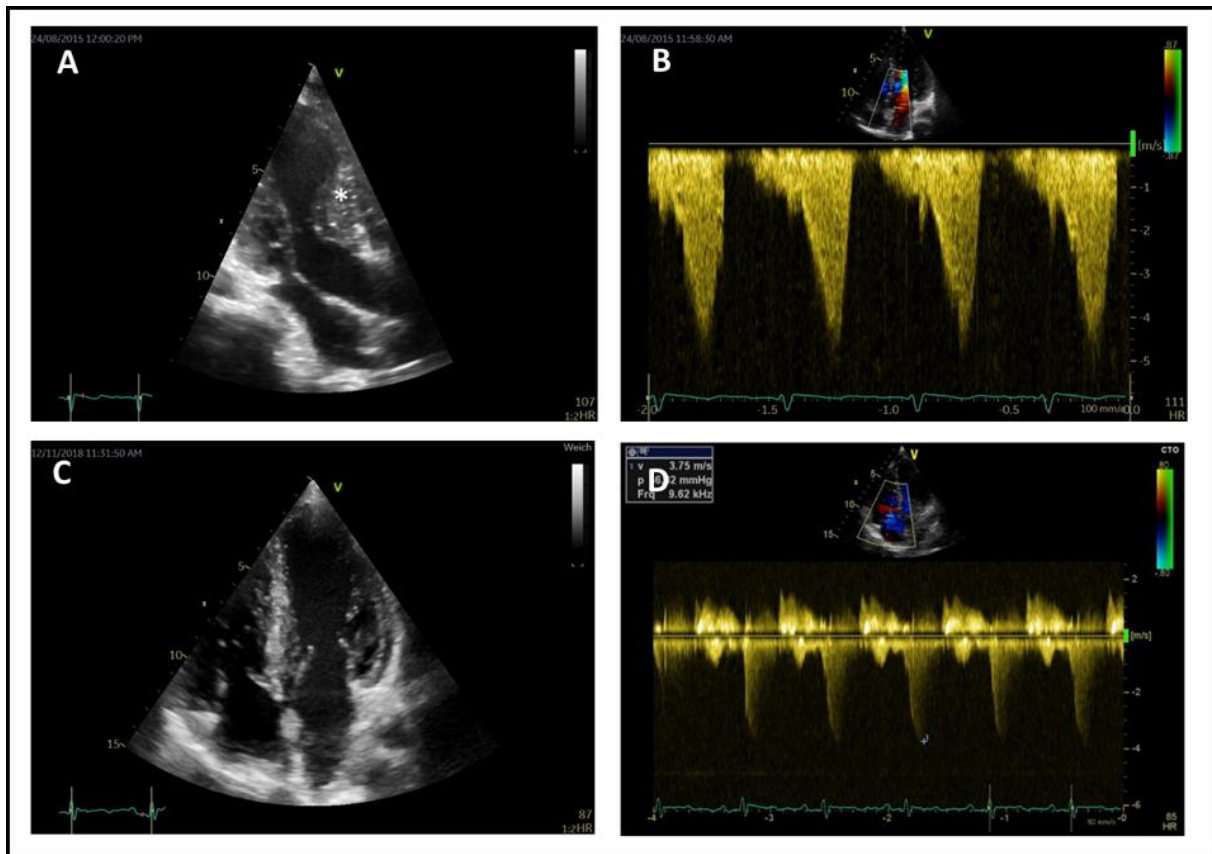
Echocardiographic images of patient 7, Related to Figure 1. Transthoracic echocardiographic imaging of patient 7 (Noonan syndrome, *PTPN11*, male, 182 months of age) at the time of admission to the hospital for surgical left ventricular outflow tract resection (panel A and B), and at the time of follow-up (220 months of age, panel C and D). Depicted are the apical 3-chamber view (panel A), the apical 4-chamber view (panel C), and the apical 5-chamber view with continuous wave (CW) Doppler (panel B and D) imaging. There is severe myocardial thickening (*), the peak gradient over the left ventricular outflow tract measures 105 mmHg before resection of the left ventricular outflow tract (panel B). There is reduced obstruction of the left ventricular outflow tract at the time of follow-up (panel D).
